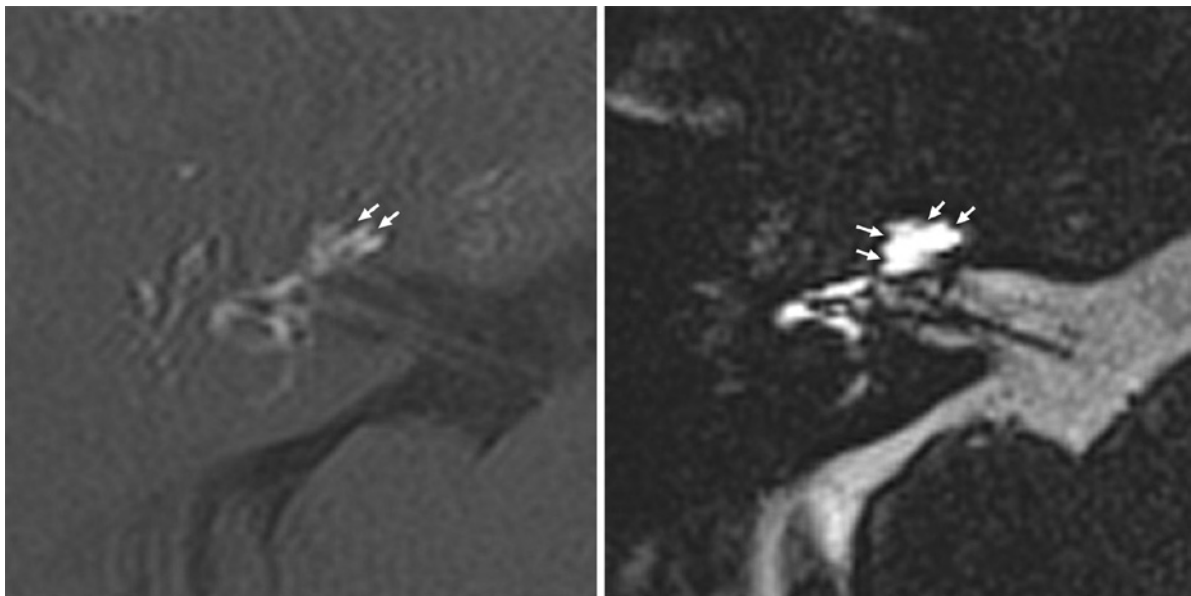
Endolymphatic hydrops in the right cochlea (arrows) in a 48-year-old female with otosclerosis (left side image; 3D real IR, right side image; heavily T2-weighted 3D FLAIR).
